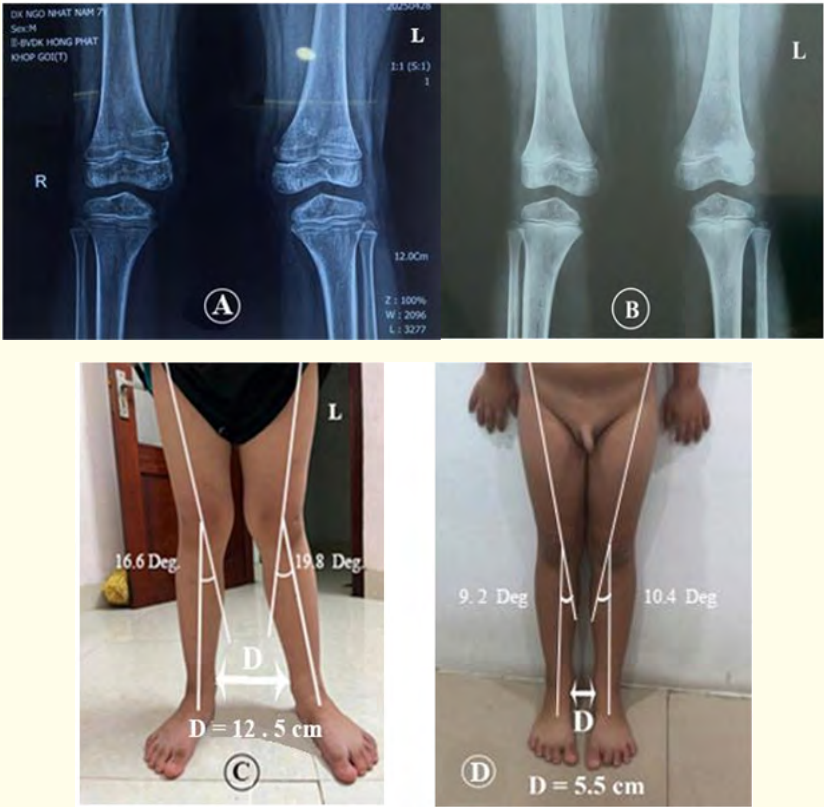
23C: 7 years 3 months old boy, Genu valgum; Operated according to temporary hemiepiphyseal stapling [31]. A. Pre-operative radiography; B. Before surgery, the distance between the 2 international ankles was 12.6 cm; Tibiofemoral angle on Left 19.8°, Right 16.6°. C. Postoperative 18 months, the distance between the 2 international ankles was 5.5 cm; Tibiofemoral angle on Left 10.4°, Right 9.2°.
